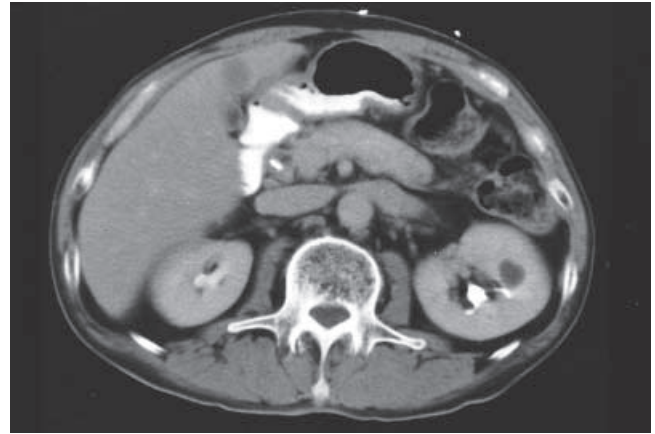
CT 2 months after the initiation of the steroid therapy shows that the swelling of the pancreas is reduced
